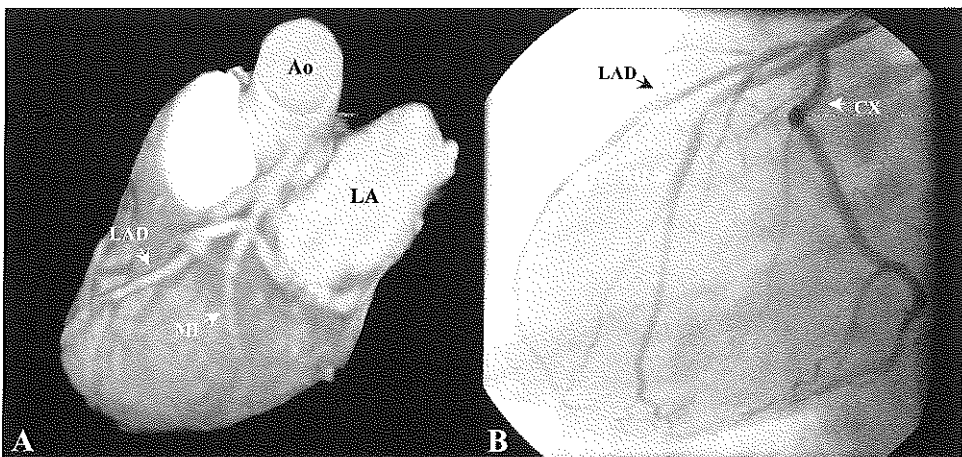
(A) Magnetic resonance imaging, trifurcation of the left main artery into left anterior descending (LAD), circumflex (CX) and intermediate (MI) arteries. Technique same as in Figure 1. (B) A conventional coronary angiogram of the same patient. Ao, aorta; LA, left atrium.
